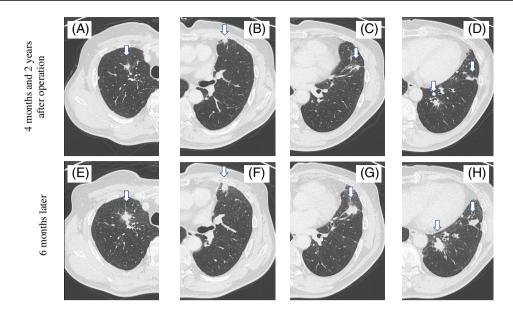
Computed tomography findings showing multiple nodules in the right upper lobe (A, white arrow), the left upper lobe (B–D, white arrows) and the left lower lobe (D, white arrow). After 6 months, the number of multiple nodules was increased (E–H, white arrows)
